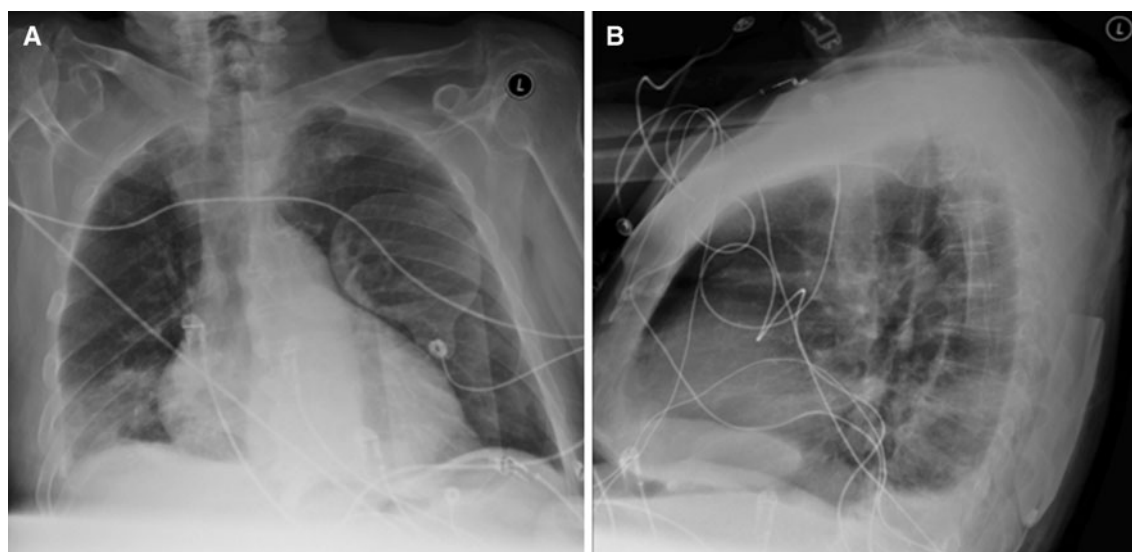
Posteroanterior (a) and lateral (b) admission chest radiograph. Admission chest radiograph revealed a small right pleural effusion with right basilar opacity consistent with pneumonia
